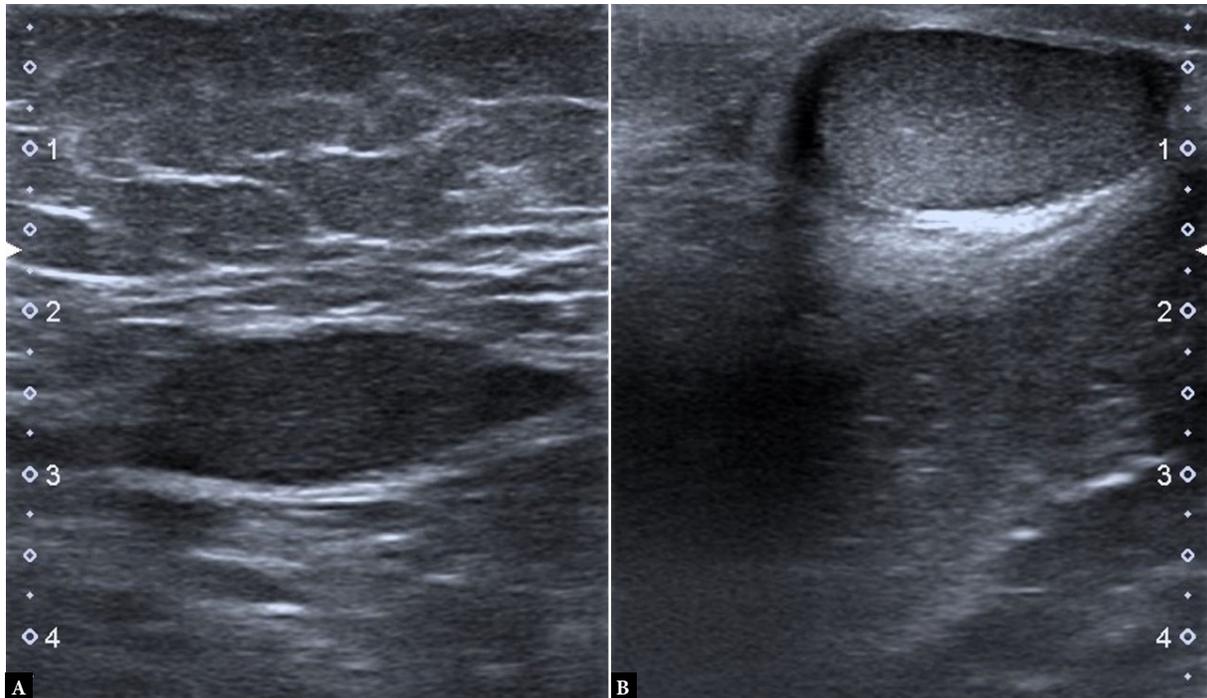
Gray-scale ultrasonography images in a 120-month-old boy. A. Deep plane undescended testis with reduced echogenicity and dimensions in the right inguinal canal. B. Image of left testis with normal echogenicity, located in the scrotum
